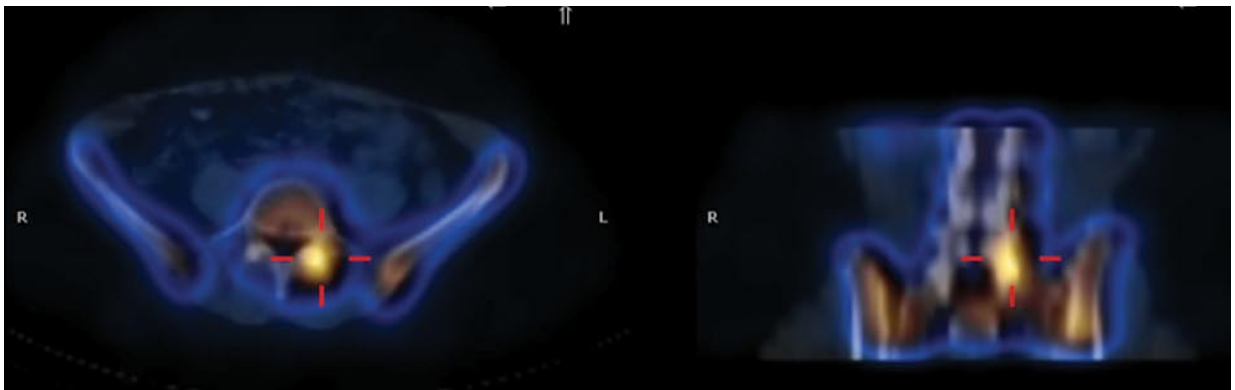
Single-photon emission computed tomography/low-resolution computed tomography fusion images show focal hot spot in L5 facet on left side.
